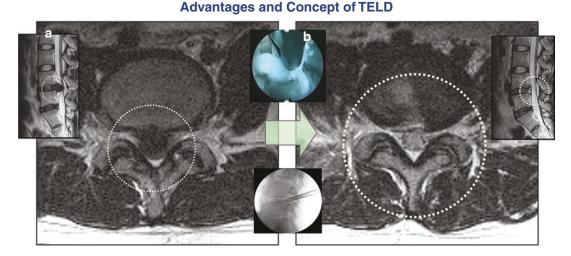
The concept and advantages of TELD. Preoperative (a) and postoperative (b) MRI demonstrates that all spinal structures were normalized after TELD. Postoperative MRI showed that there were no
